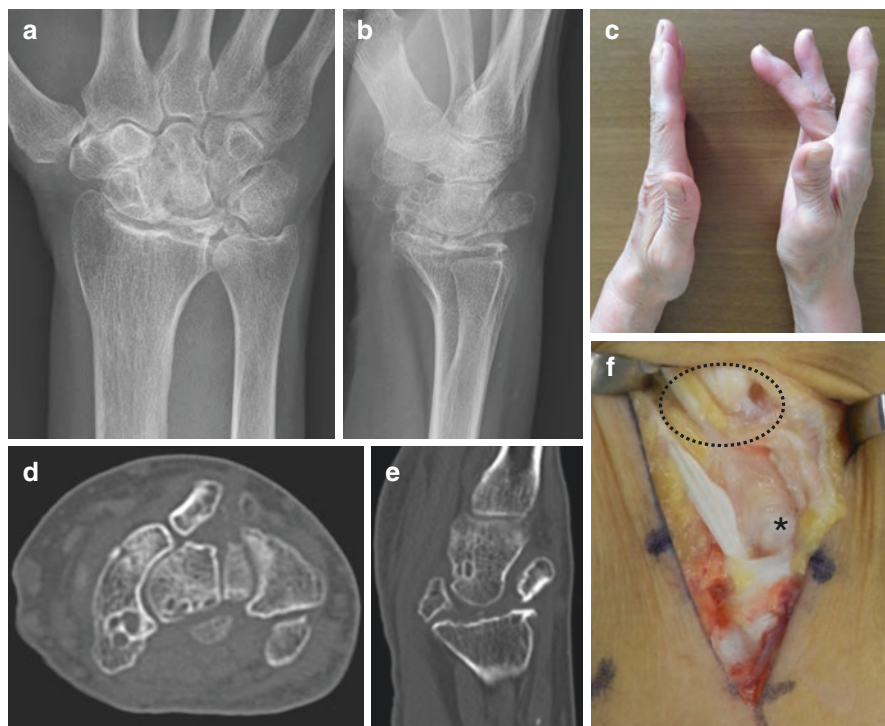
Kienböck's disease with extensor tendon rupture. (a) A 69-year-old woman visited our hospital complaining of difficulty extending her right middle finger. (b, c) Plain radiograph exhibited fragmentation of the lunate. (d, e) Computed tomography images revealed one of the fragments of the lunate protruding dorsally. (f) Extensor indicis proprius and extensor digitorum communis of the middle finger were ruptured (dotted circle). The dorsal capsule was ruptured by the dorsal fragment of the lunate (asterisk)
